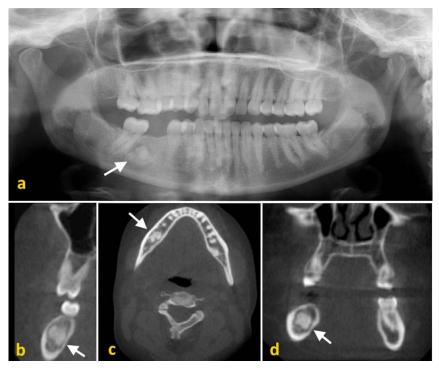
(a) The panoramic radiography of FOD. The CBCT image of FOD: (b) sagittal, (c) axial, and (d) coronal section showed a radiopaque mass, well circumscribed, and surrounded by a radiolucent halo.
